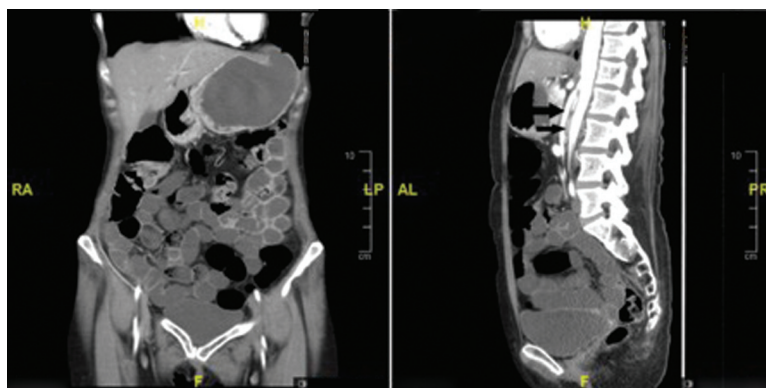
Preoperative contrast-enhanced computed tomography scan showing normal stomach distention (left) with the sagittal angiogram (right) showing compression of the duodenum (lower arrow) between the superior mesenteric artery (upper arrow) and the aorta.
